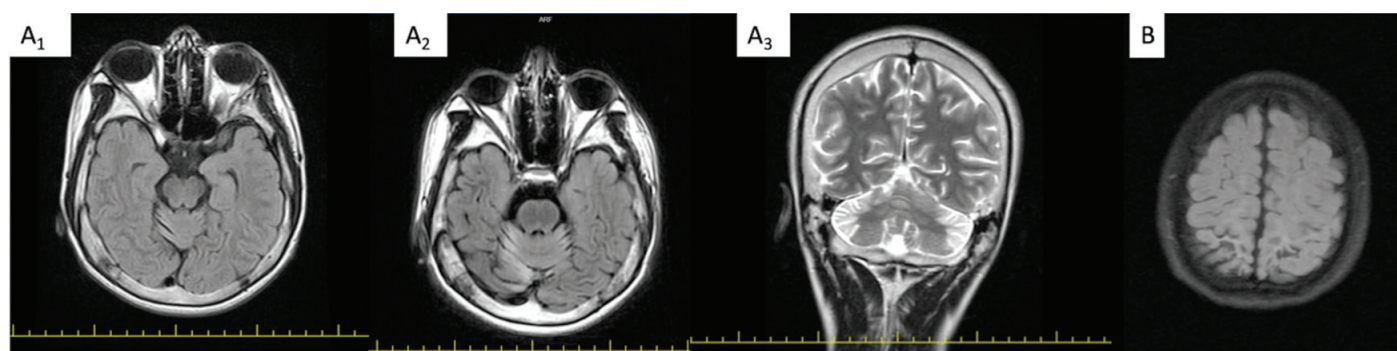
The brain MRI captures of the patients with structural changes. A₁₋₃, Cerebellar atrophy in cranial MRI in patients with mutation at *GRM1* (patient no.6 in Table 1). B, Bilaterally parietooccipital encephalomalacia in patients with deletion at 15q15.1 (patient no.2 in Table 2)
